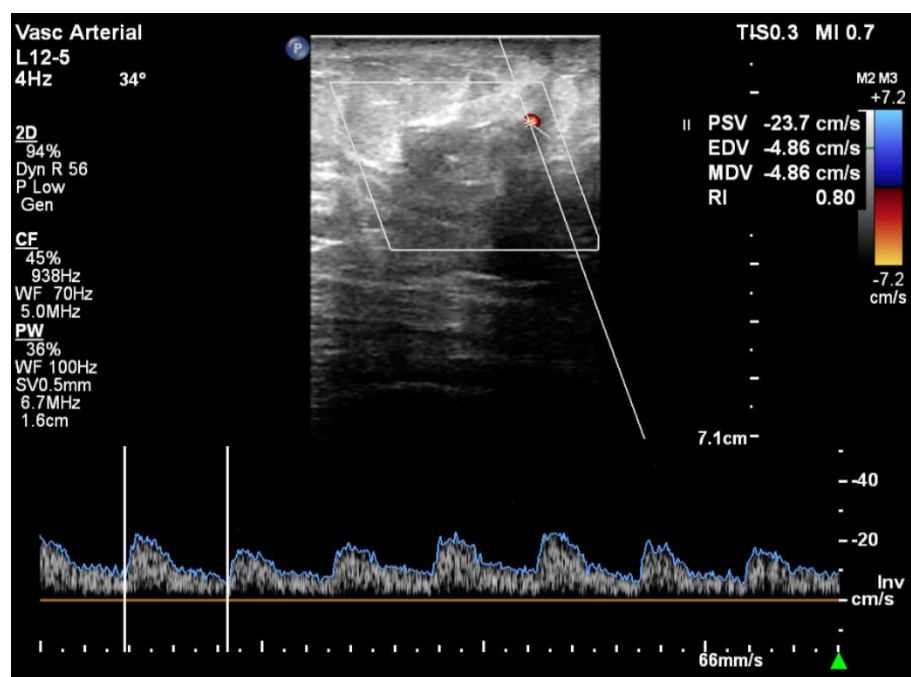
On Doppler interrogation internal vascularity was noted with PSV of 23.7, RI of 0.8 and PI of 0.88.
